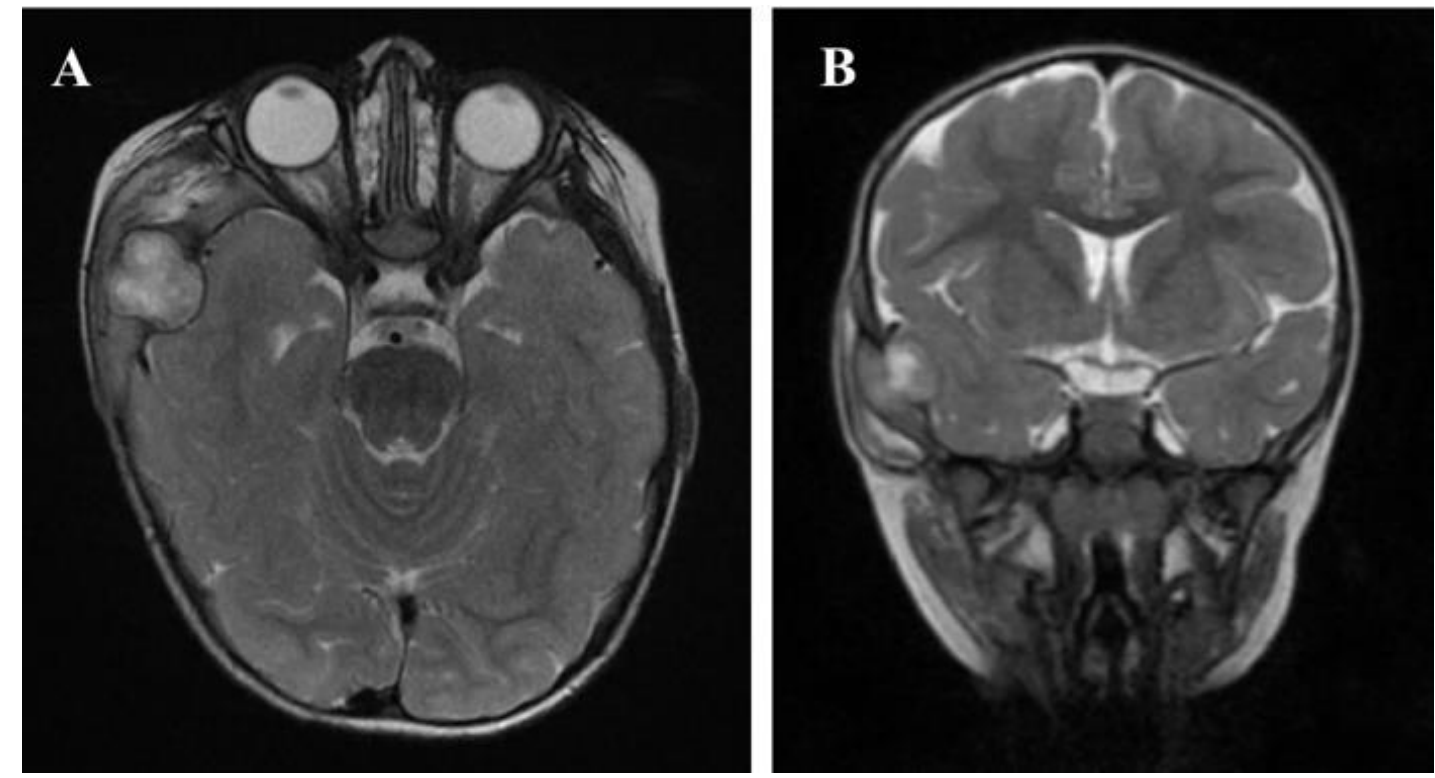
Preoperative imaging. (A-B) MRI showing an expansive lesion in the right temporal diploic region, measuring 20x24x27 mm
